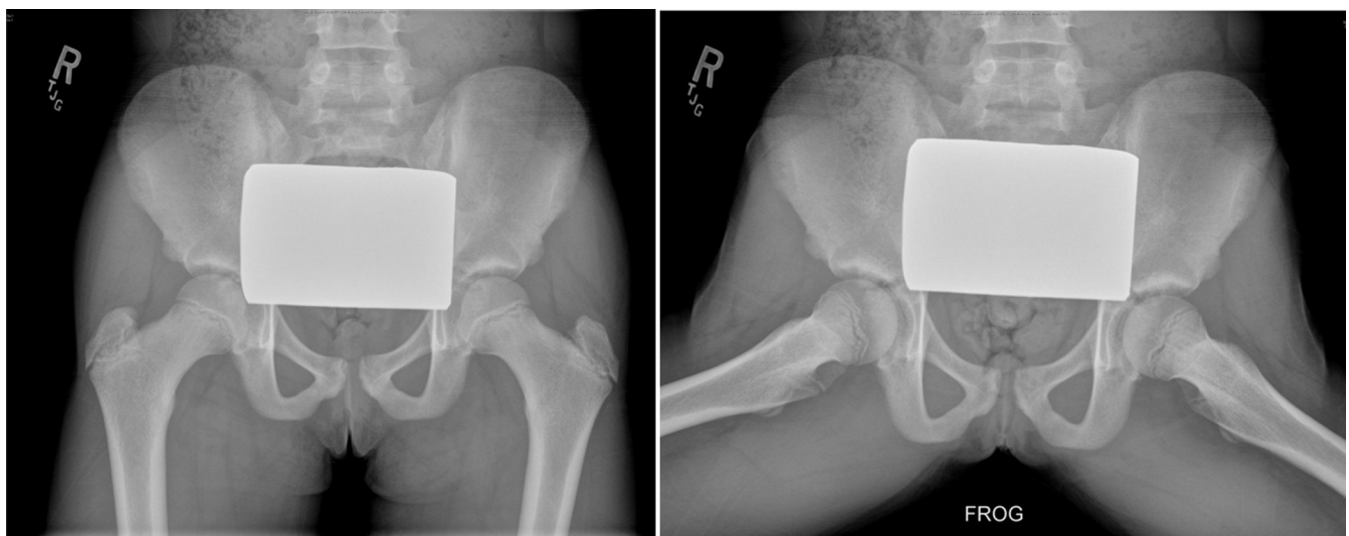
Normal radiograph imaging: AP pelvis (left) and bilateral frog leg lateral (right).
